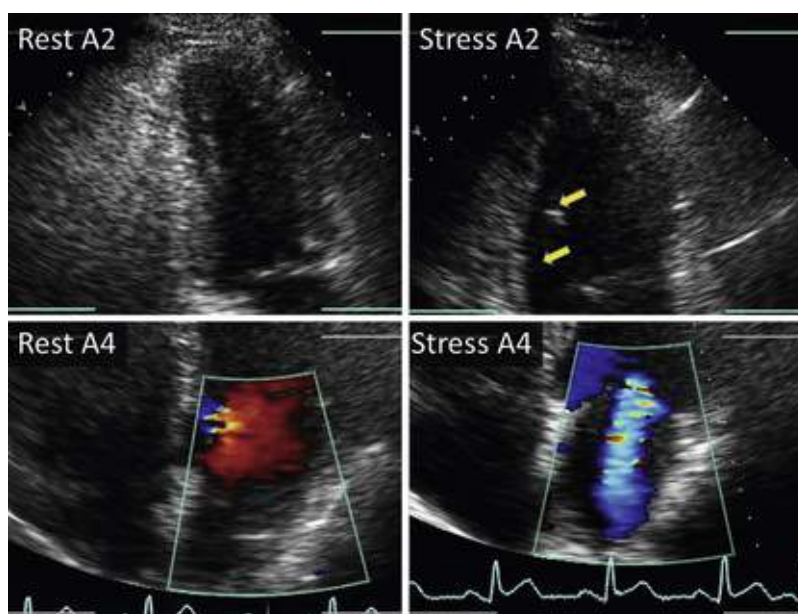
Stress echocardiography with evidence of ischemia in the right coronary artery (RCA) territory and acute ischemic MR. Resting and stress echocardiograms in the apical two-chamber (A2) and apical four-chamber (A4) views with color Doppler reveal new stress-induced inferior hypokinesis (*arrows*) in the area containing the posteromedial papillary muscle and increased MR. This patient was found to have 90% stenoses of the RCA and left circumflex artery on cardiac catheterization. (See Video 14.25.)
